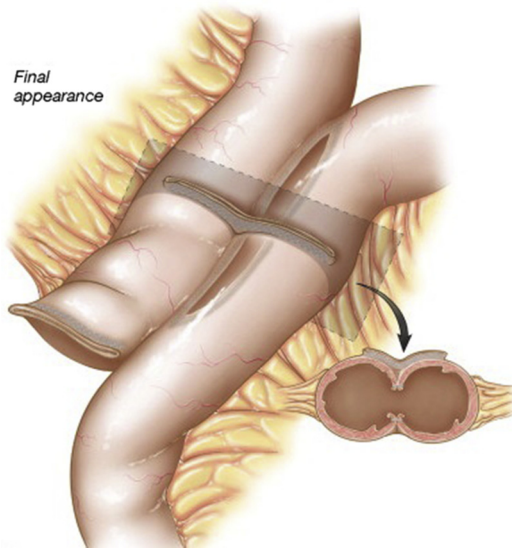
Perpendicular orientation of staple lines, and completed jejunojunction utilizing the Frantzides-Madan triple-stapling technique. (From Zografakis JG, Frantzides CT. Laparoscopic Gastric Bypass with Roux-en-Y Gastrojejunostomy. In: Frantzides CT, Carlson MA, editors. Atlas of Minimally Invasive Surgery. Philadelphia: Elsevier Saunders; 2009. p. 53–66; with permission.)
